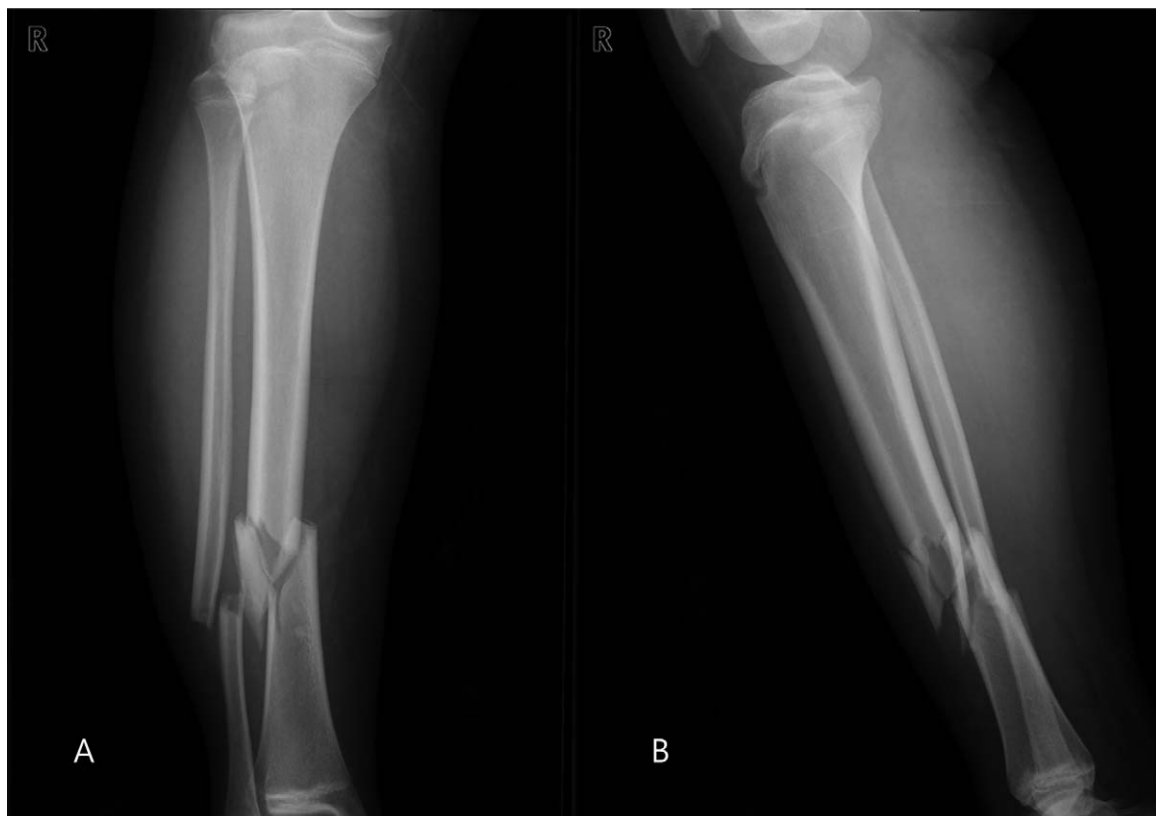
Preoperative plain anteroposterior (A) and lateral (B) radiographic views of the right lower leg showing a fracture of the distal tibio-fibular shaft.
